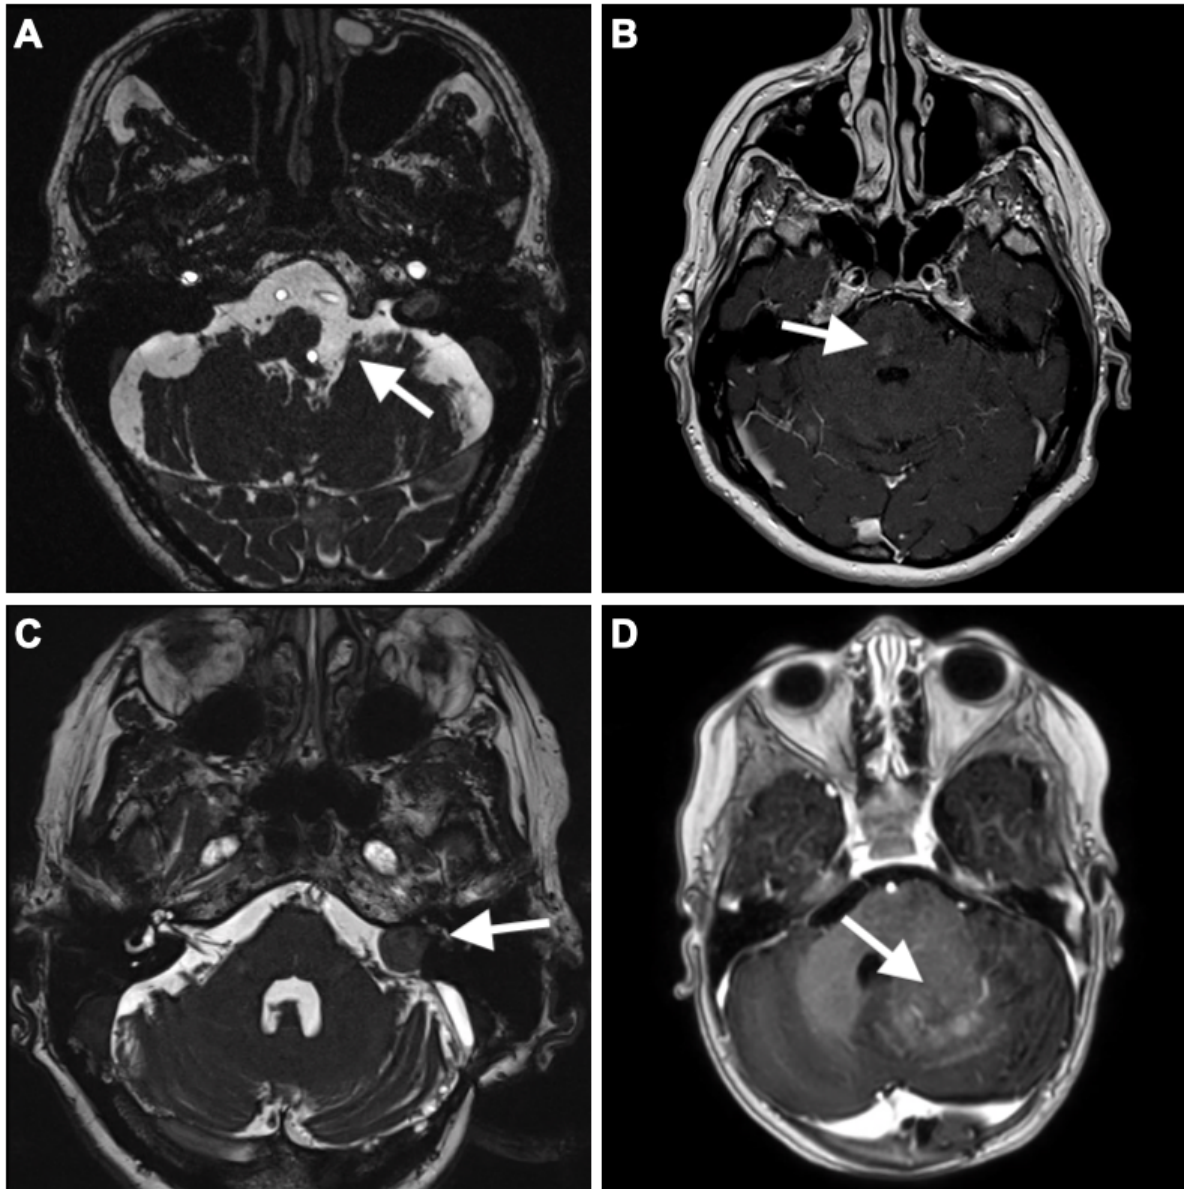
Conventional MR scan of the brain in HFS. (A) 3D-T2 weighted sequence (CISS), axial slices at the level of the cerebellum, of a 67-year-old man presenting a compression of the bulbo-pontic junction by an ectatic left vertebral artery. (B) T1-weighted sequence post-gadolinium contrast, axial slices at the level of the cerebellum, of a 65-year-old man presenting a telangiectasia in the right paramedial part of the pons. (C) CISS axial slices at the level of the cerebellum, of an 80-year-old woman presenting a compression in the left cerebellopontine angle by an acoustic neuroma. (D) T1-weighted sequence post-gadolinium contrast, axial slices at the level of the cerebellum, of a 5-year-old girl presenting a cerebello-pontine ganglioglioma (mutation BRAF V600E).
